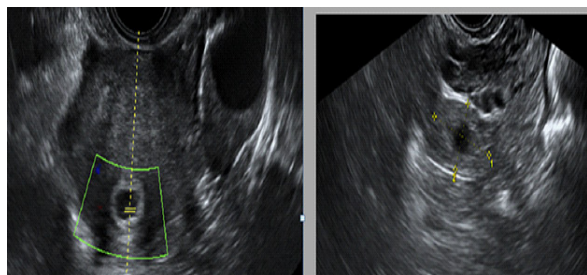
Pelvic ultrasound showing the intrauterine pregnancy (gestational sac with diameter 5 mm, absent fetal echo) and extrauterine left adnexal pregnancy with diameter 20x 20 mm.
